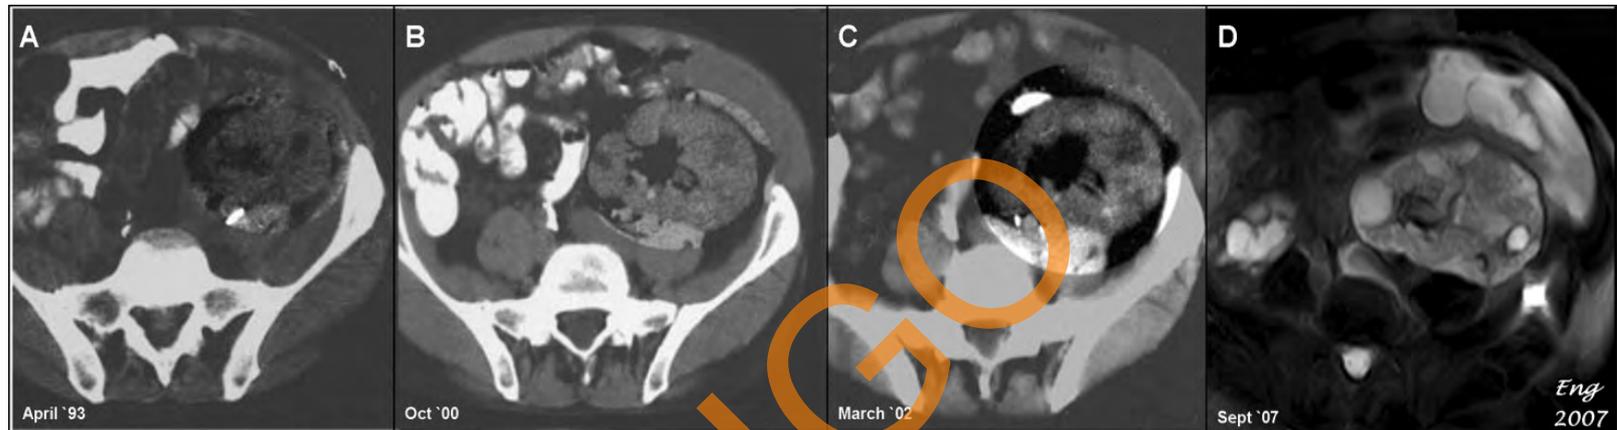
The slow progression of disease in the patient's ADPKD donor kidney is evident with serial imaging, which date from (A) April 1992, (B) October 2000, (C) March 2002, and (D) September 2007 (T2-weighted MRI). During this time, the largest cyst...
